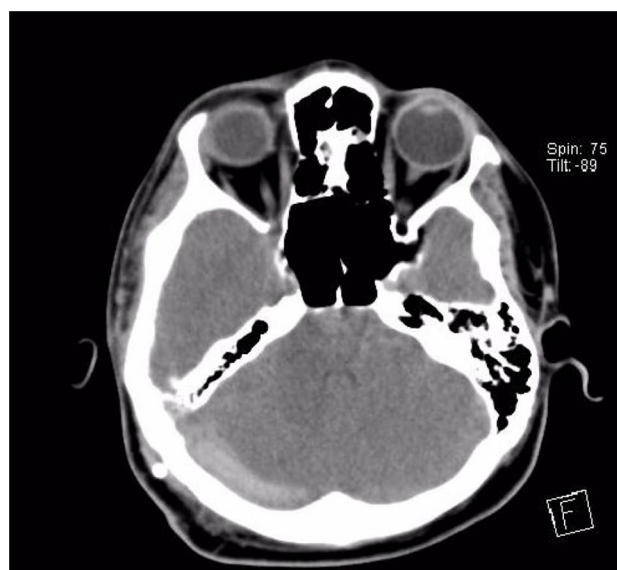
Brain computed tomography on the first day after readmission showing spontaneous hyperdensity in the right transverse sinus
